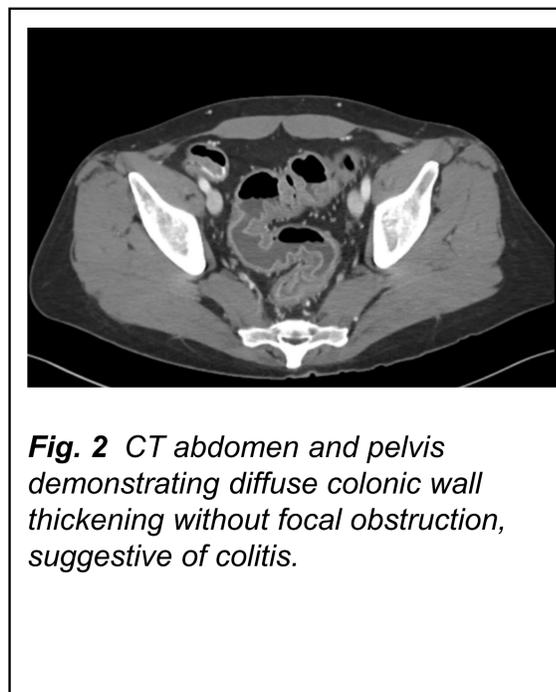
CT abdomen and pelvis demonstrating diffuse colonic wall thickening without focal obstruction, suggestive of colitis.
